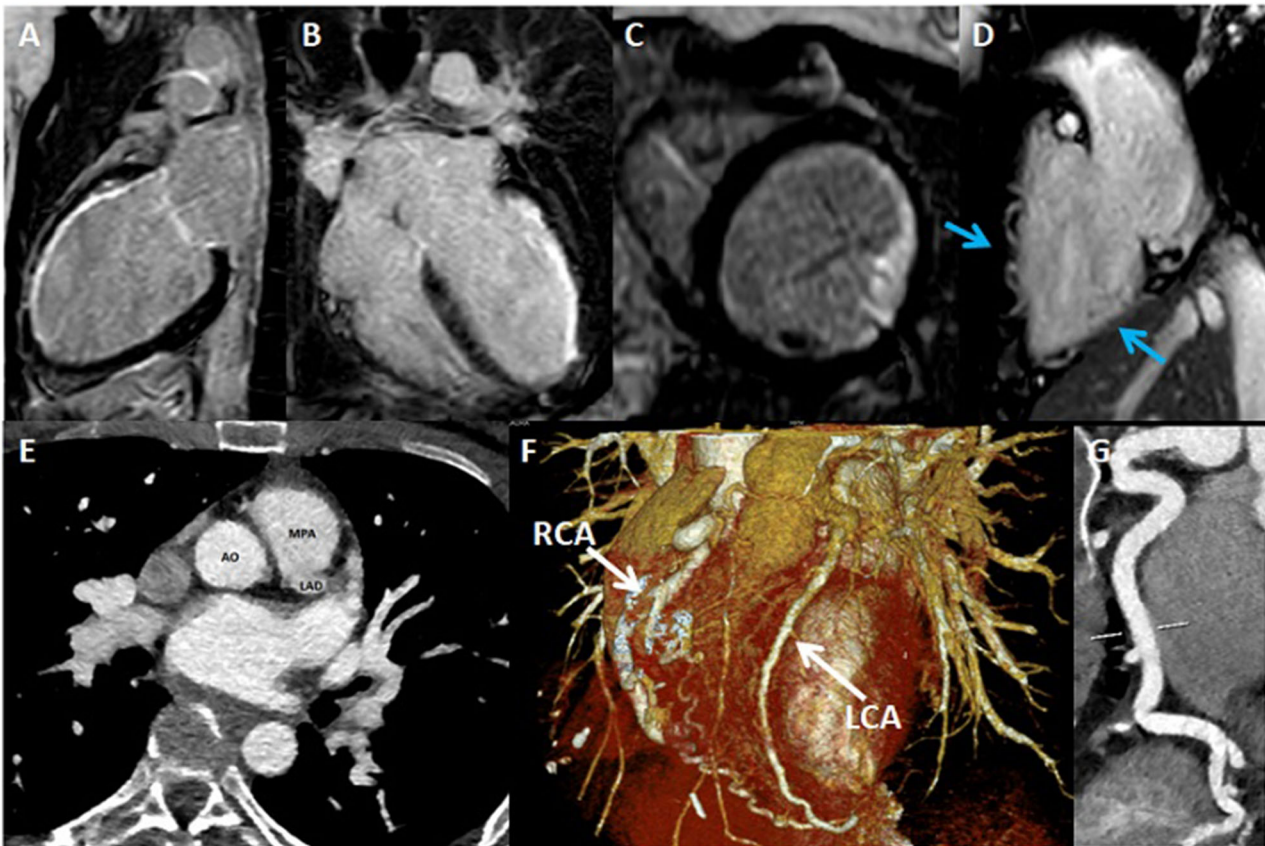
LGE sequences, 2-chambers view. Figure B: LGE sequences, 4-chambers view. Figure C: LGE sequences: short-axis view, LGE involves anterior papillary muscle. Figure D: 2-chambers view, collateral circulation (light blue arrows). Figure E: Axial multidetector CT angiogram shows the origin of the left coronary artery from the main pulmonary artery (MPA). Figure F: 3-D rendering of multidetector CT angiogram which shows the origin of the right coronary artery (RCA) and the left coronary artery (LCA). Figure G: CT image of a dilated RCA.
